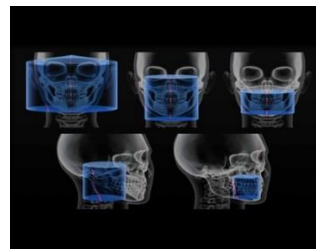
Scanning volumes – FOVs in dental CBCT imaging (Puthenpurayil et al. 2015)
